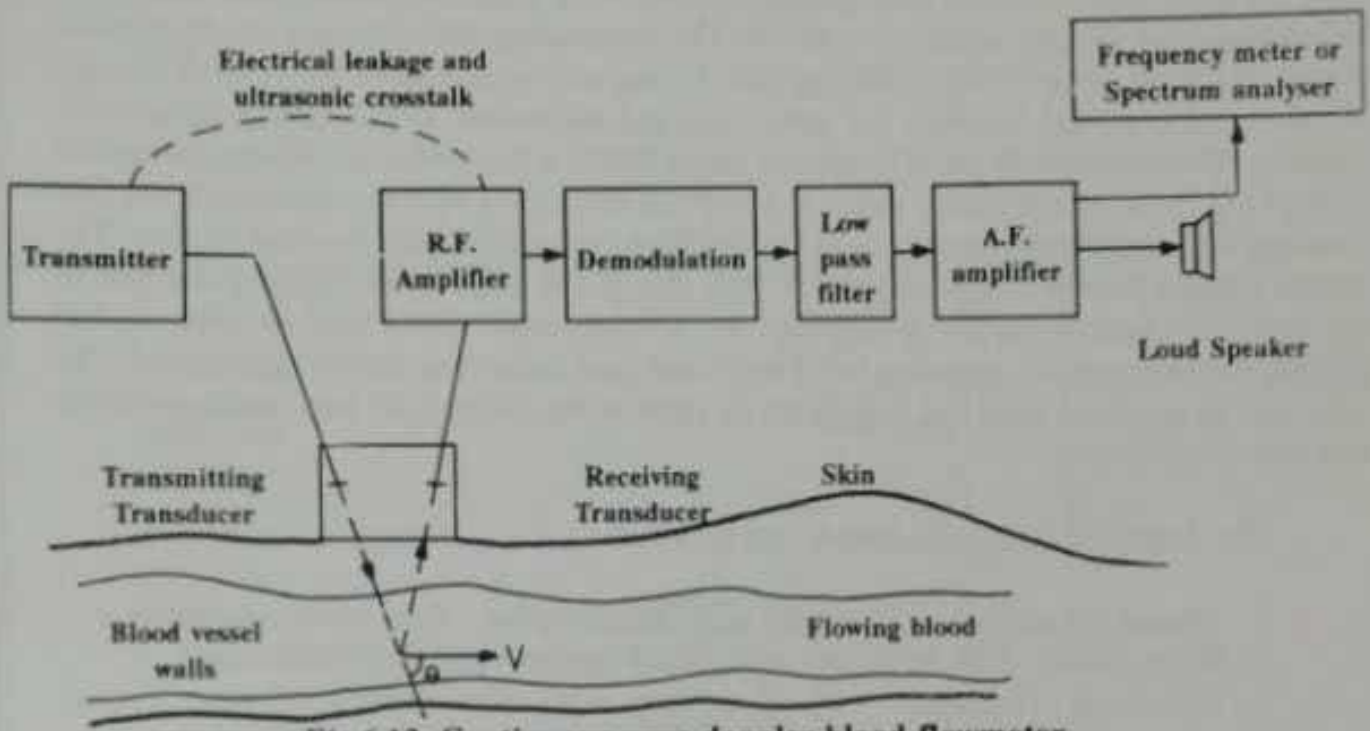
Continuous wave doppler blood flowmeter
